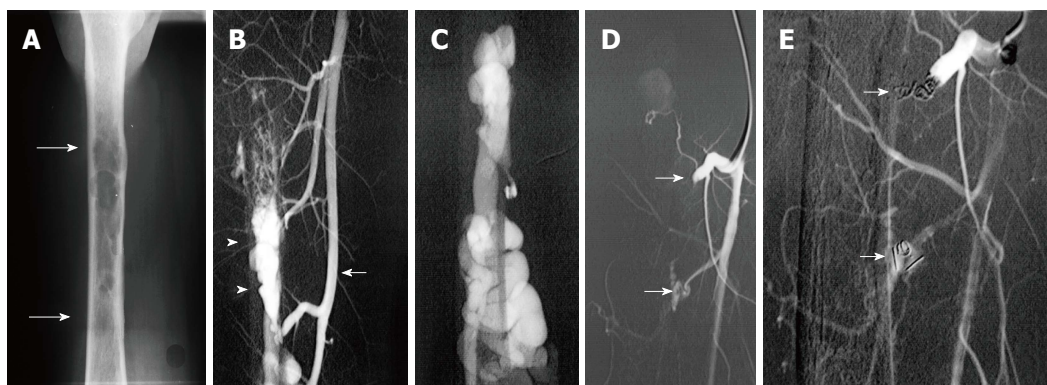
Use of detachable coils, released only when satisfactory placement is achieved, may increase the safety of the procedure. Radiograph of the mid-diaphysis of the femur demonstrates a region of endosteal erosion (arrows) (A). Arteriography demonstrates a multifistulous malformation with arterial supply from two muscular branches of the superficial femoral artery (arrow) with early filling of intraosseous venous drainage (arrowheads) (B, C). Occlusion of the feeding arteries was accomplished with large coils (arrow) eliminating the fistulous communications (D, E).
